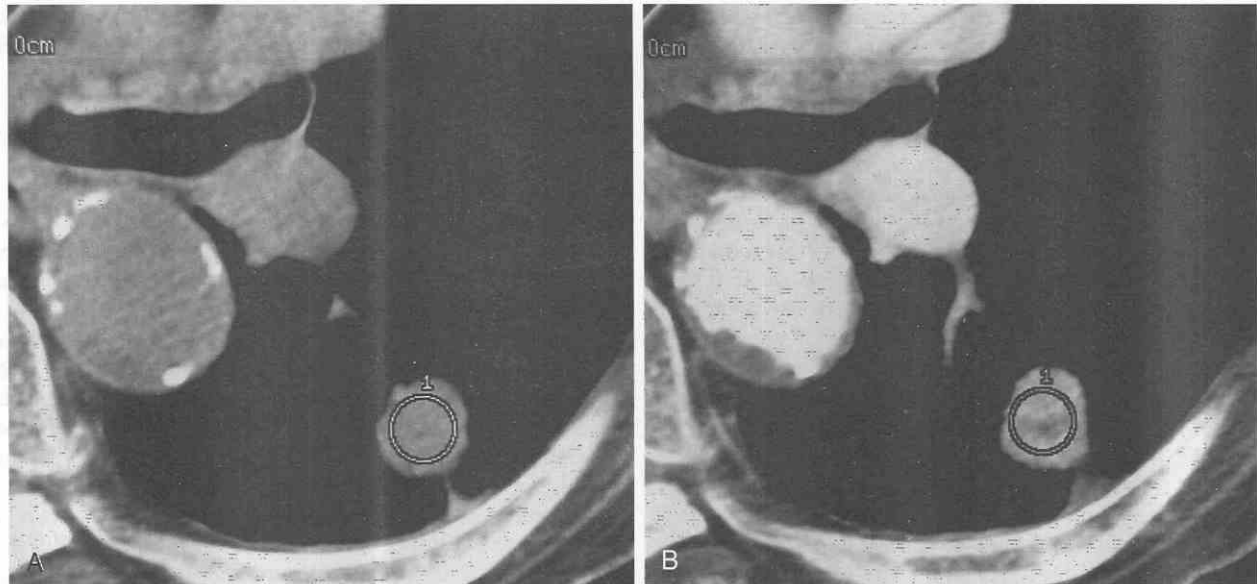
Non-small-cell cancer appearing as an enhancing nodule after administration of contrast material. *A*, Non-contrast-enhanced CT scan shows a left lung nodule with an attenuation value of 24 Hounsfield units (HU). *B*, Contrast-enhanced CT scan shows nodule enhancement of 70 HU and central necrosis. Enhancement of more than 20 HU suggests malignancy. Resection revealed non-small-cell cancer. (Courtesy of Tom Hartman, M.D., Mayo Clinic, Rochester, Minn.)
